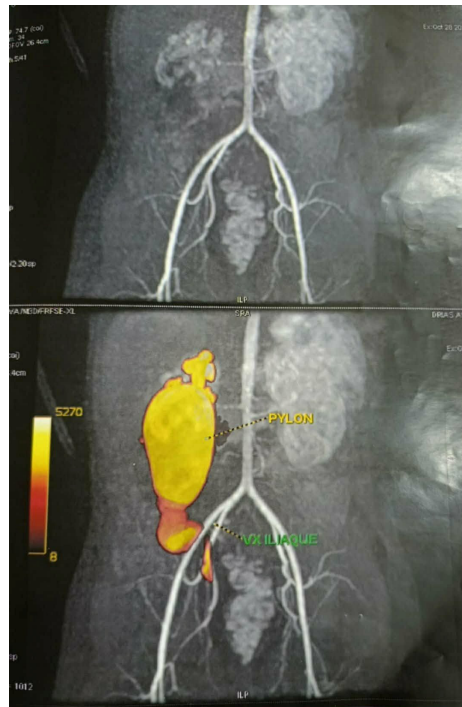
A uro-MRI performed in the patient showing a right retro-iliac syndrome.
